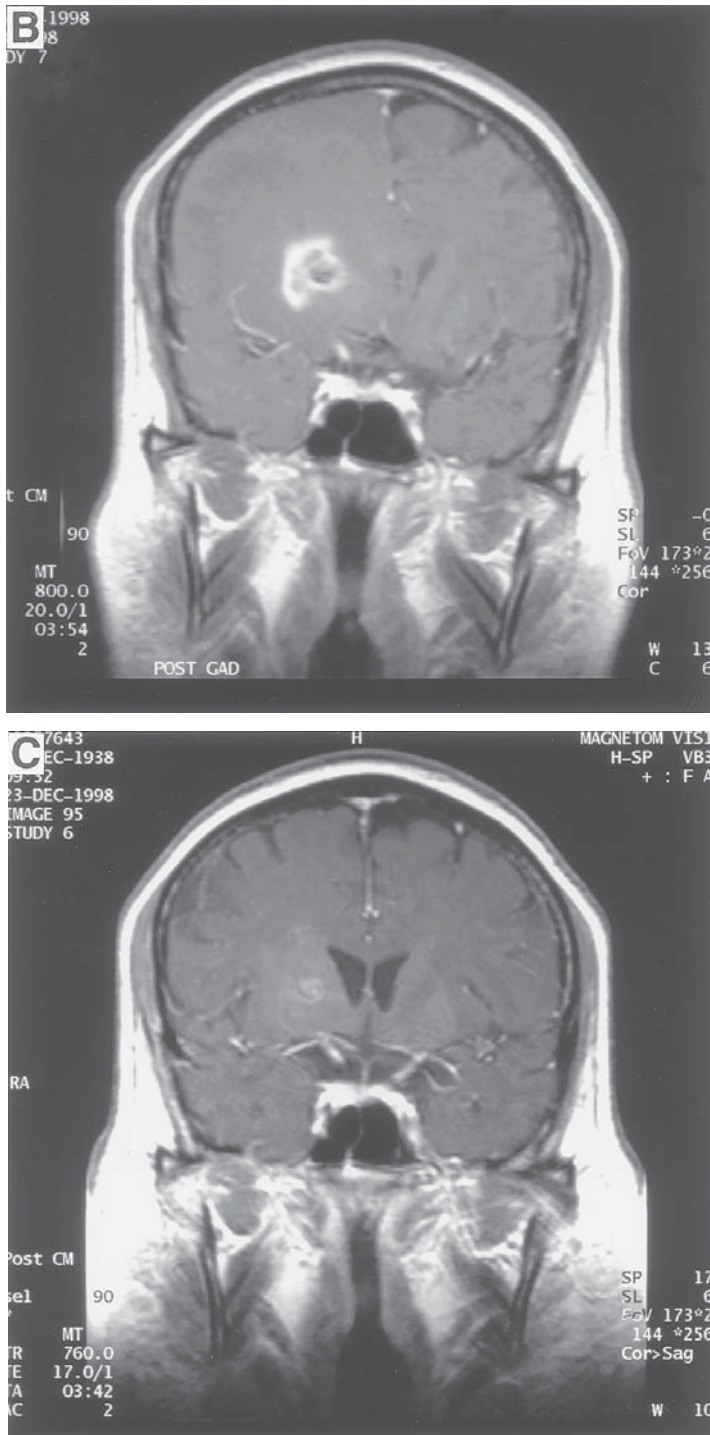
(Continued). (B). Posttreatment MRI after Gamma Knife radiosurgery alone (2500 cGy prescribed to the 72% isodose line). Scan demonstrates radiation necrosis with midline shift and compression of the ventricles (7 mo status post Gamma Knife radiosurgery). (C) Scan demonstrates resolution of radiation necrosis with decreased tumor size and ventricular compression after 6 wk of steroids. Patient's Karnofsky performance status at follow-up was 90.
